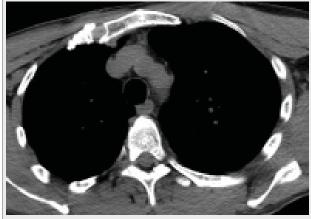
Axial CT image showing a vertical mid-sternal, slightly displaced fracture.
